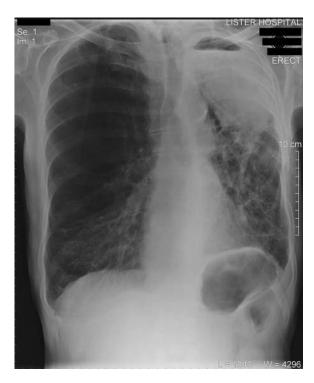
Presenting chest radiograph showing a large fluid-filled cavity in left upper lobe. The lungs are overinflated with emphysematous change in both lung fields.
